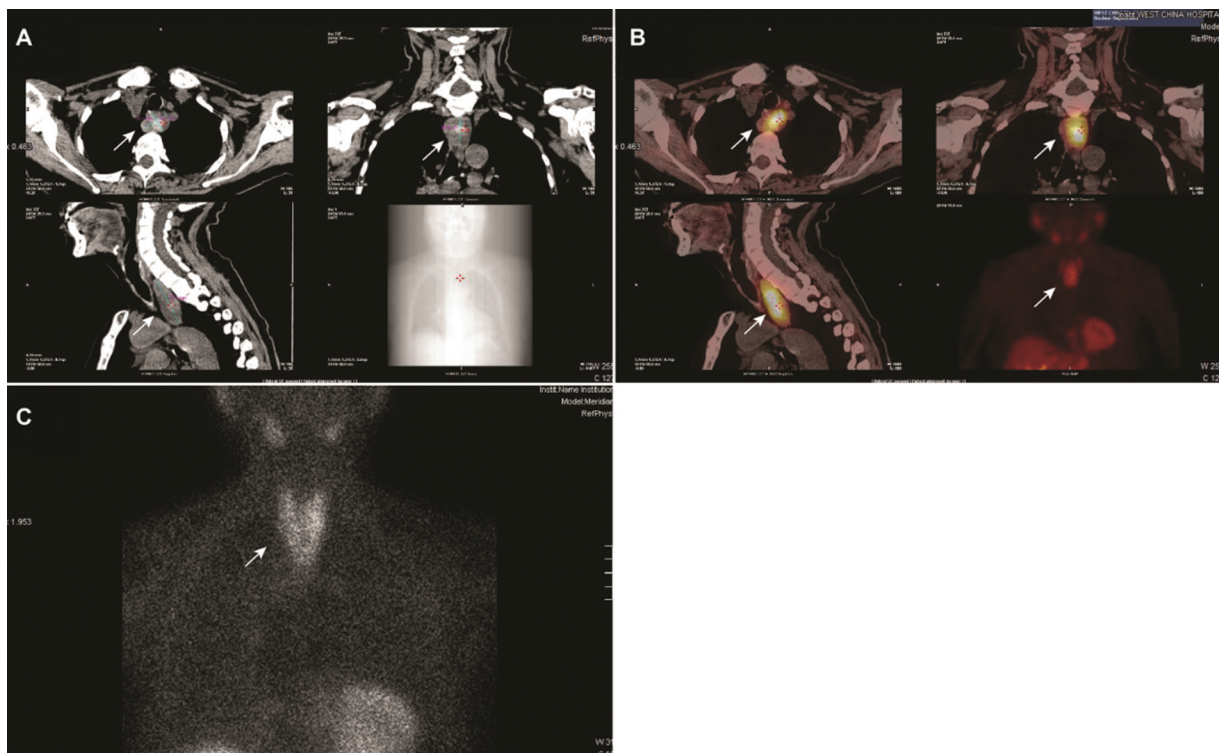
Ectopic mediastinal parathyroid adenoma in preoperative imaging. (A) Adenoma on computed tomography (CT) scan (white arrow). (B) and (C) Technetium 99m sestamibi images of adenoma (white arrow) and the merged images with CT scan.
